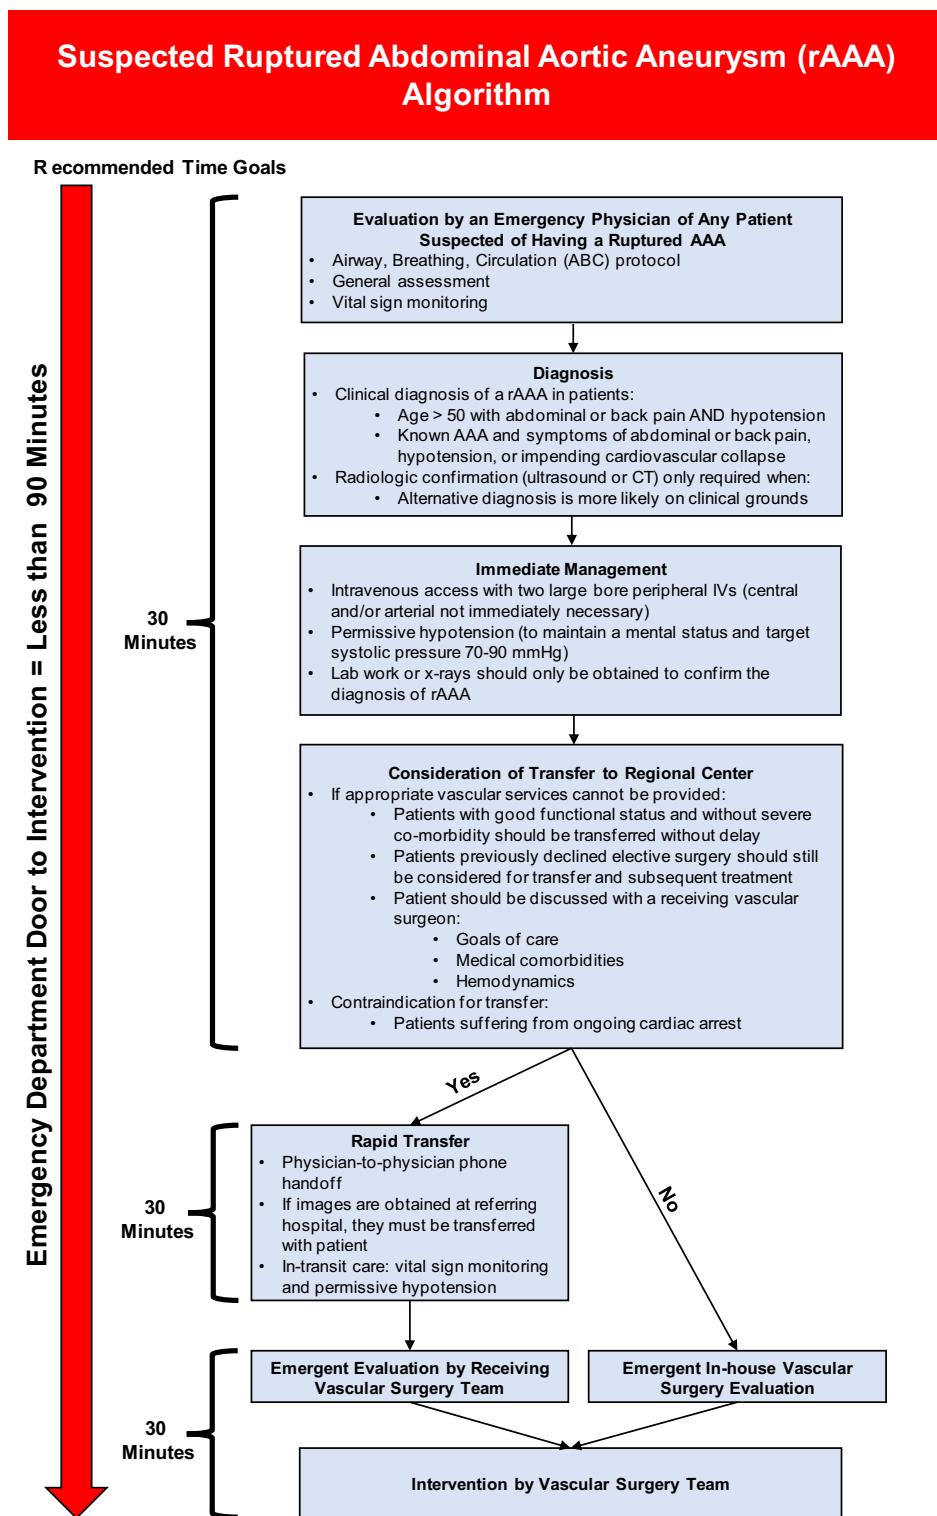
Algorithm for management of the patient with a suspected or confirmed ruptured abdominal aortic aneurysm (AAA). CT, Computed tomography; IVs, intravenous lines.
